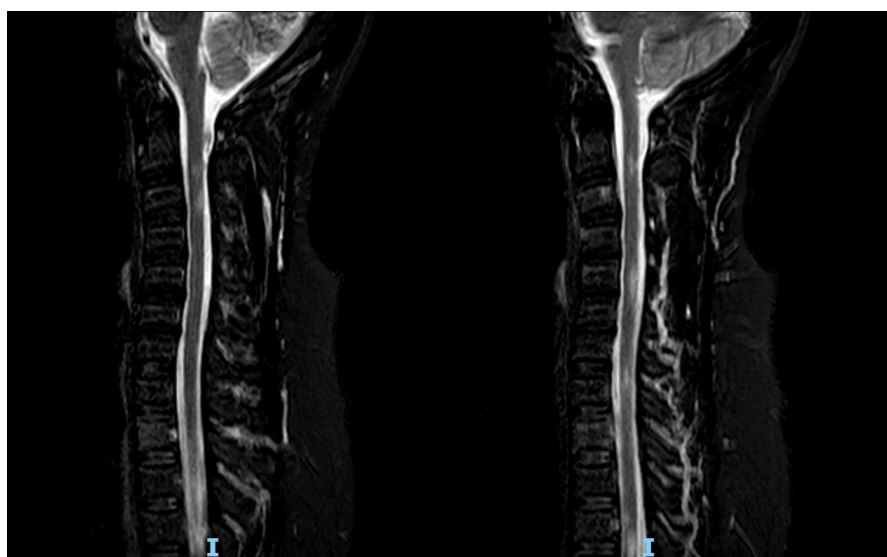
MRI cervical spine showing three-level lesions (C2/3, C5, C6/7), confirming MS.
